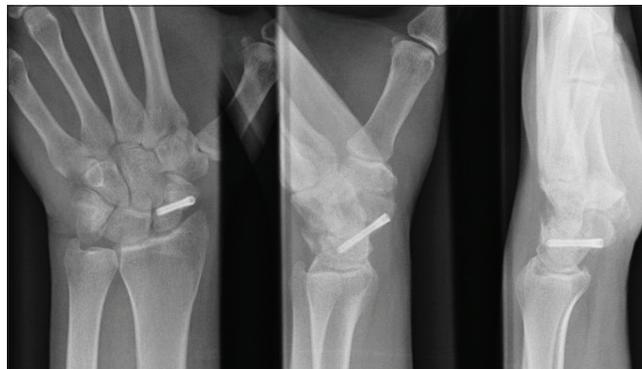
Plain radiographs showing healing across the scaphoid non-union with compression screw in situ at 14 weeks post-operative period.
